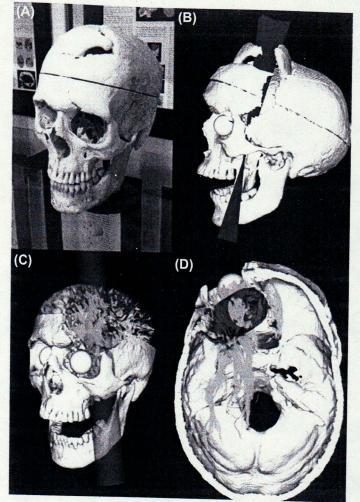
The reconstruction of the damage to Phineas Gage's head from the tamping iron. (A) The actual skull of Phineas Gage is on display at the Warren Anatomical Museum at Harvard Medical School. Note the damage done by the tamping iron at the top of the skull where the iron exited. (B) Computerized tomography (CT) scans were made of the skull and a reconstruction was made showing the hypothesized location of the tamping iron (shown in *red*) as it passed through the skull and brain. (C) A rendering of the tamping iron and the brain fibers that were likely damaged in the accident (shown in *green*). (D) A top view of the fibers that were likely damaged in the accident—in this view, the left hemisphere is shown on the left of the image, and the forehead and face areas are shown at the top of the image. *Source: van Horn et al.* (2012).
